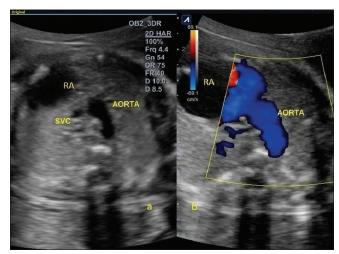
Gray scale and color Doppler three-vessel view at 29 weeks of pregnancy. Only two vessels aorta and superior vena cava (SVC) are visualized. Unorthodox malpositioned "I" shaped aorta. Ductus arteriosus and pulmonary artery are not seen. RA: Right atrium
